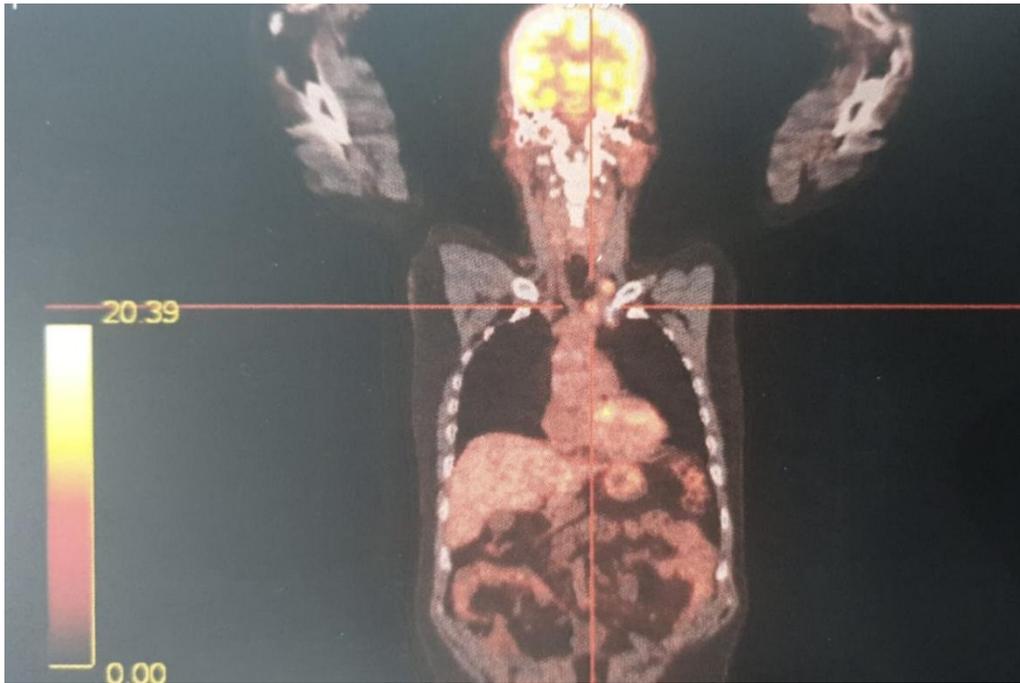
18-FDG PET scan of our patient showing two hypermetabolic nodular retro and supra-sternal left foci.
